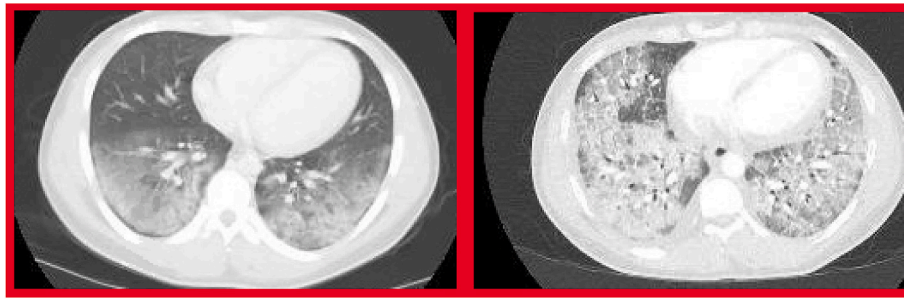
Comparison of CT scan images from admission (left) to intubation (right).
